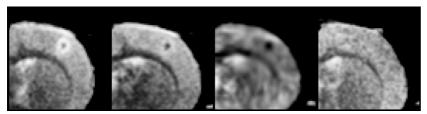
Magnetic resonance images of the size evolution of a tumor after an irradiation of the whole hemisphere at 15 Gy. The first image from the left is prior to the irradiation, the three following were acquired 4, 9 and 36 days after the irradiation.
